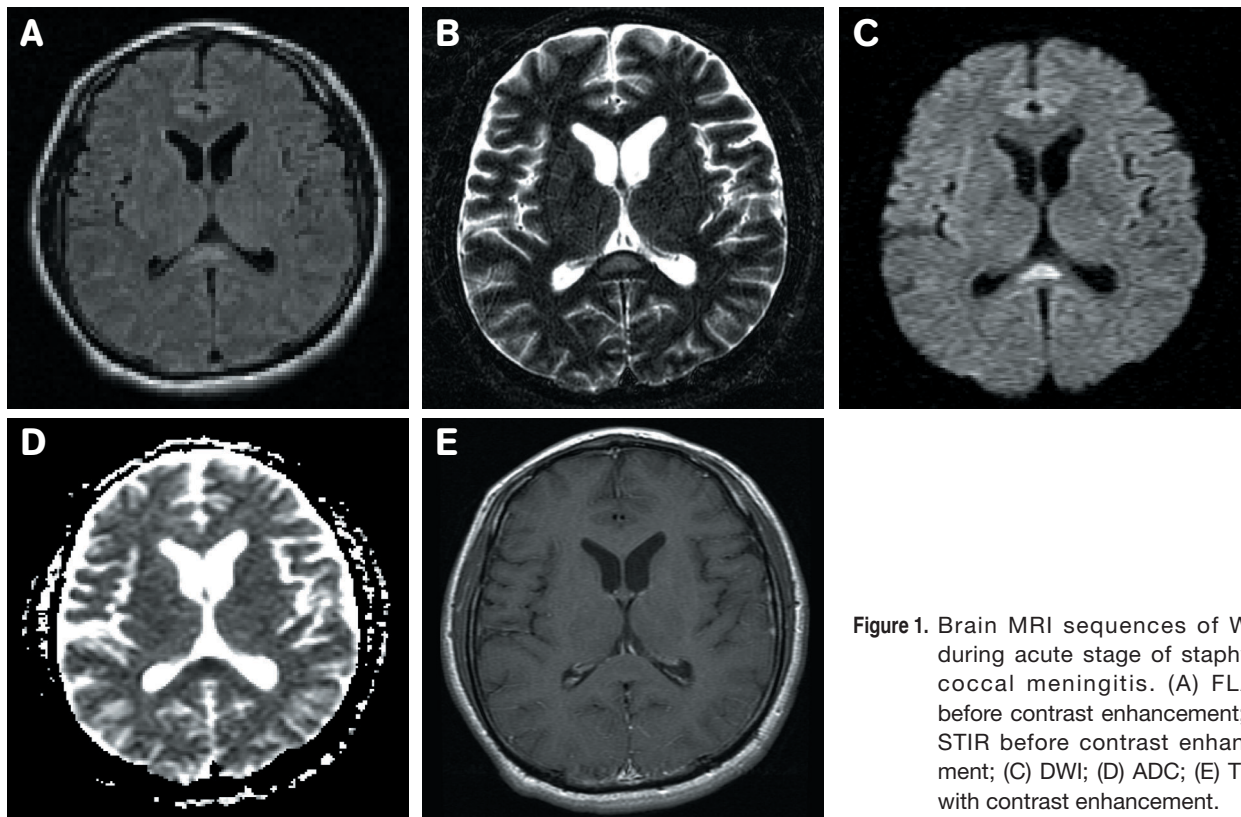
Brain MRI sequences of W.S. during acute stage of staphylococcal meningitis. (A) FLAIR before contrast enhancement; (B) STIR before contrast enhancement; (C) DWI; (D) ADC; (E) T1WI with contrast enhancement.
